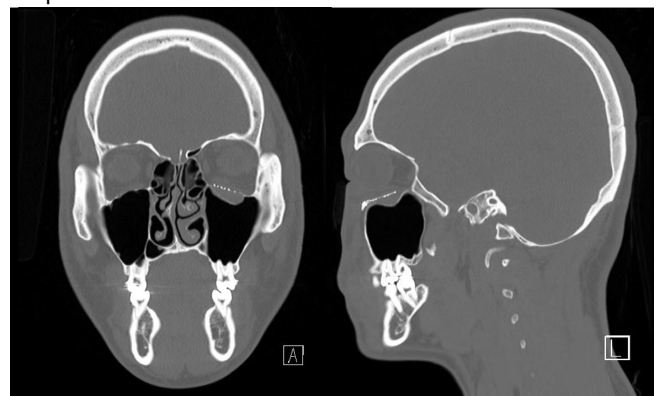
Postoperative CT showing restoration of the orbital floor contour after reconstruction with Medpor Titan.
